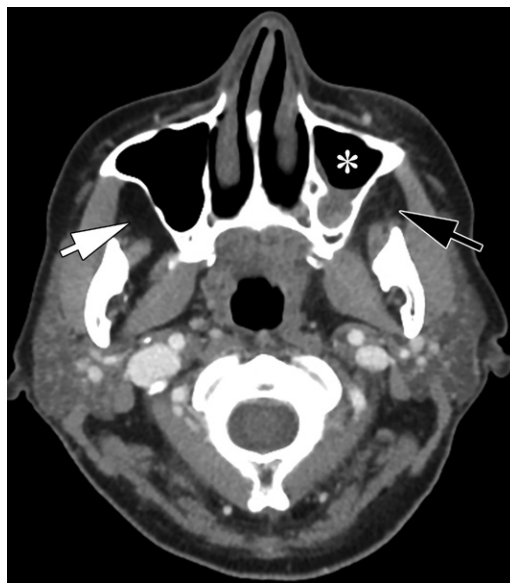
Mucor* sinusitis in a 59-year-old woman with diabetes. Axial contrast-enhanced CT image shows an air-fluid level (confirmed on other images, not shown) in the left maxillary sinus (*), consistent with sinusitis. Classic periantral fat stranding (black arrow) is seen on the left, as compared with the normal periantral fat (white arrow) on the right. The findings in this case show that minimal sinus opacification does not exclude the diagnosis of invasive fungal sinusitis.
